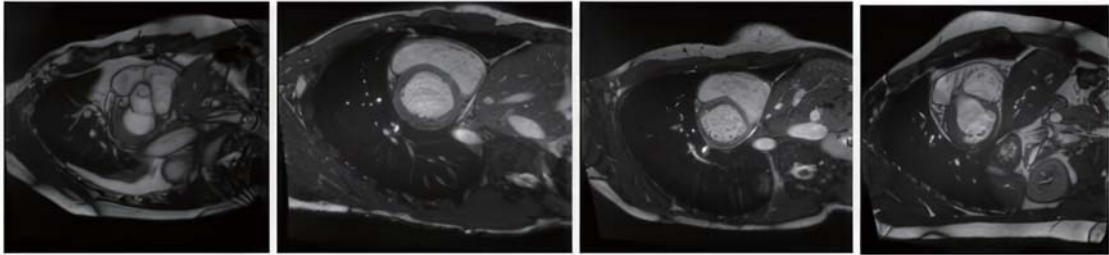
Cardiac MRI. [4]
